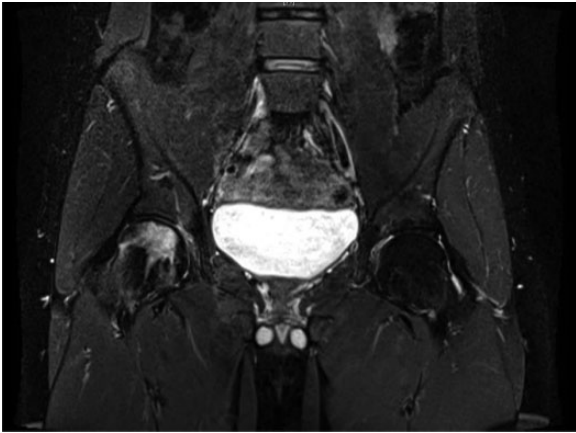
Coronal T2 magnetic resonance imaging obtained 3 months after injury. The image demonstrates edema within the superior portion of the right femoral head. No significant subchondral collapse is evident. There is subtle loss of sphericity without collapse.
